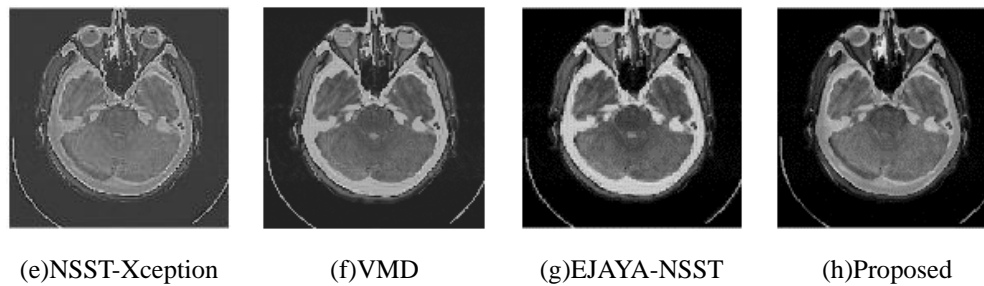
Qualitative outcomes of speech arrest (CT-MRI-T2)
